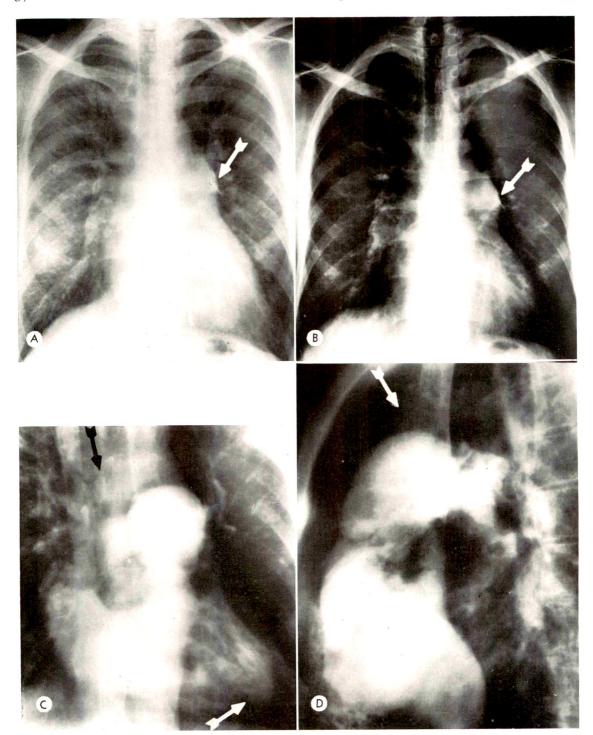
Case II. (A) Frontal teleroentgenogram of the chest showing enlargement of the heart and pulmonary artery. Note calcification of the pulmonary artery (arrow). (B) Overpenetrated frontal roentgenogram of the chest showing the pulmonary arterial calcification to advantage (arrow). (C) Frontal intravenous angiocardiogram showing the enlarged right atrium, ventricles, and pulmonary artery. There is faint opacification of the left ventricle (white arrow) and ascending aorta (black arrow). (D) Lateral angiocardiogram (biplane of C) also shows the enlarged pulmonary artery and left branch. Note the large thrombus occupying the outer lower half of the left pulmonary artery (arrow).
